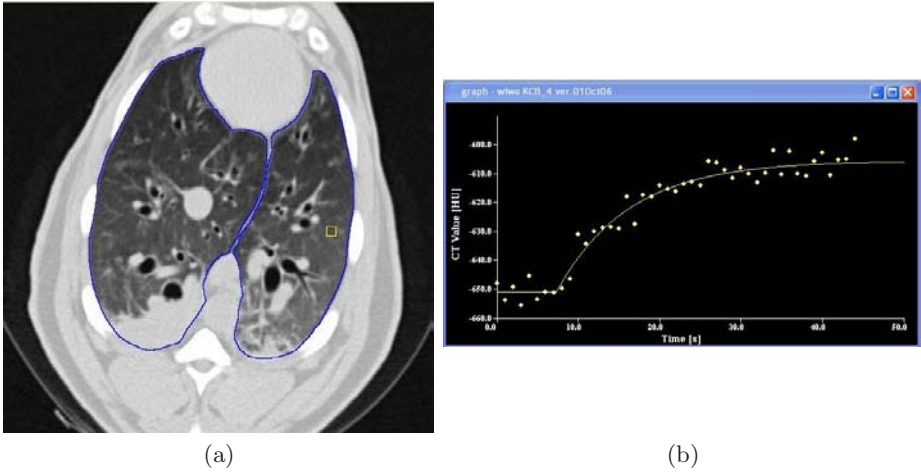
Time series data from Xe-CT study. (a) shows the Xe-CT image of the lungs, with the lung boundaries marked in blue and a rectangular region of interest in yellow. (b) shows the raw time series data for this region of interest (wash-in phase) and the associated exponential model fit.
